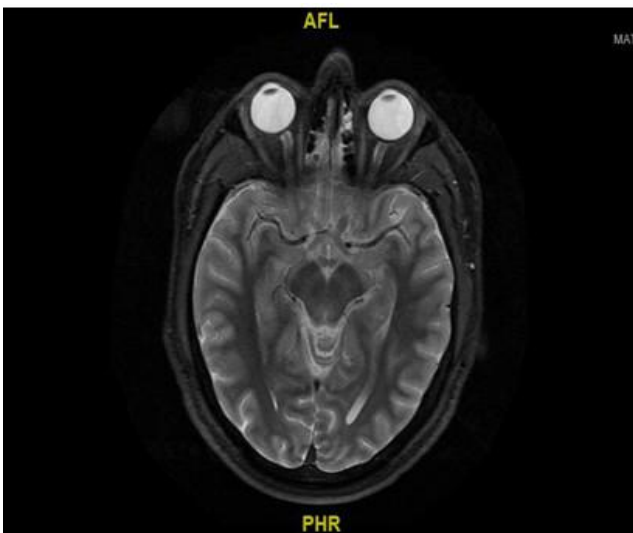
Plain MRI performed while the patient was not on steroid therapy
